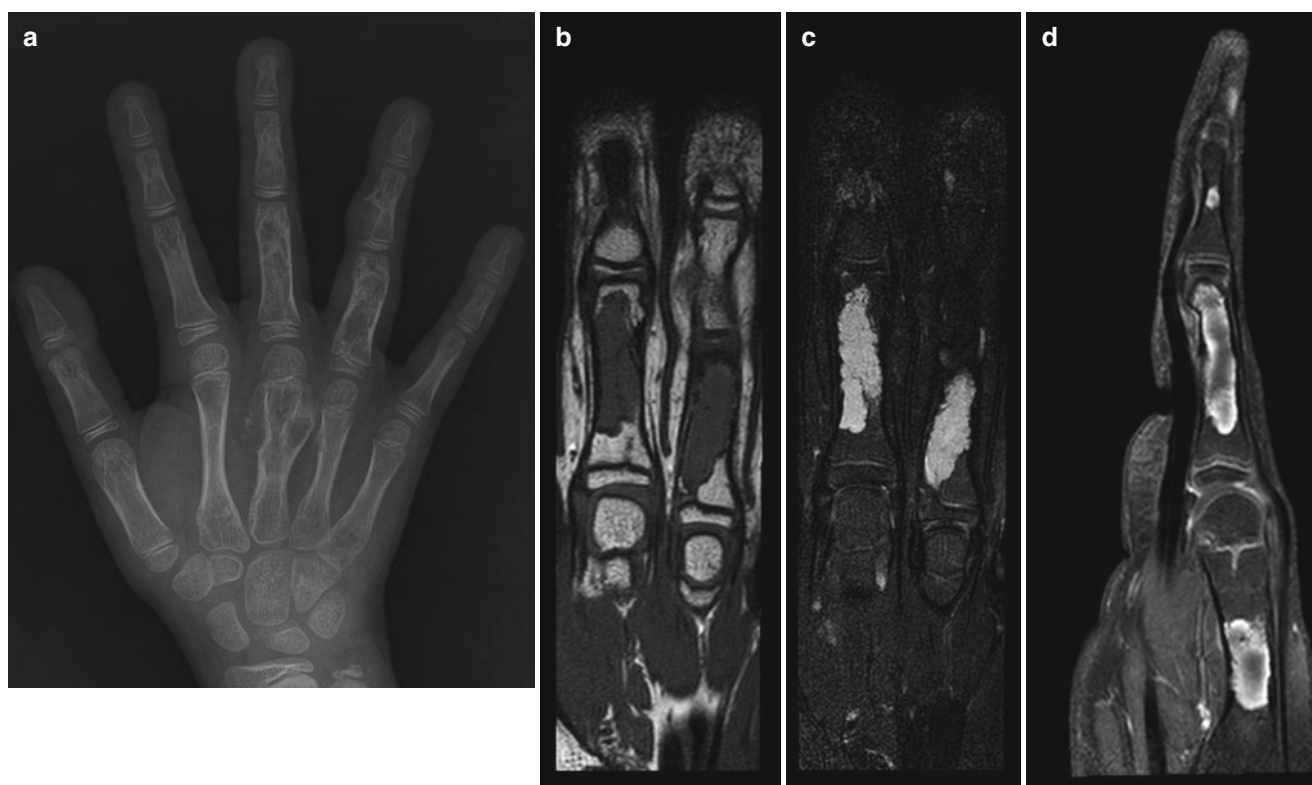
Enchondromas in an 11-year-old boy.* (a) Left-hand radiography shows relatively well-demarcated osteolytic lesions involving the short tubular bones of the hand with coarse trabeculations within the lesions. (b–d) MR T1-weighted coronal (b), STIR coronal (c), and postcontrast T1-weighted sagittal (d) images reveal well-demarcated
